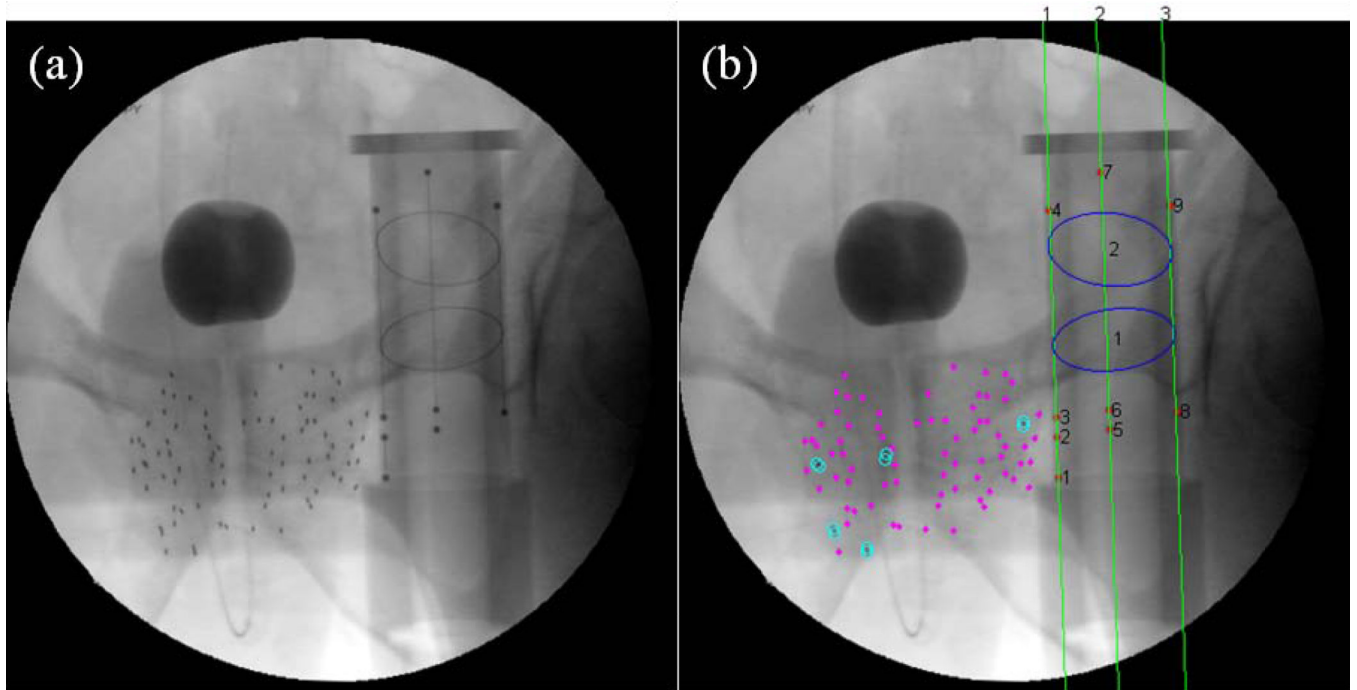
Sample clinical study segmentation. (a) Inputted original X-ray image. (b) Outputted segmentation of FTRAC lines (green), BBs (red dots), and ellipses (blue) as well as single (magenta dots) and overlapping (cyan circles) seeds overlaid on X-ray image.
